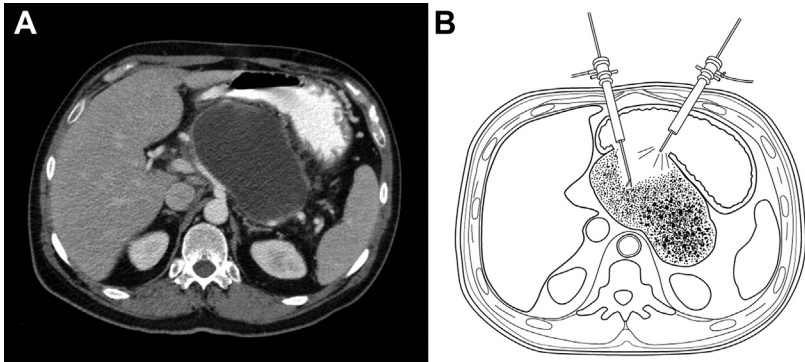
Surgical transgastric necrosectomy. (A) Computed tomography axial imaging of a large retrogastric walled-off pancreatic collection with a large area of contact with the posterior gastric wall. (B) During laparoscopic transgastric necrosectomy, after obtaining pneumoperitoneum, the stomach is insufflated to achieve contact between the anterior stomach and abdominal wall so that radially dilating trocars can be placed directly into the stomach. A laparoscope and other instruments are used to proceed with debridement.
